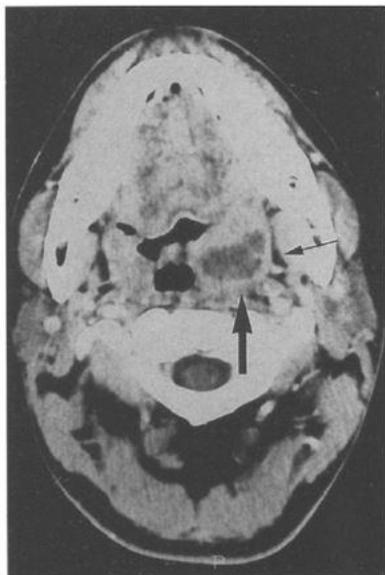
Postcontrast CT scan at level of oropharynx, showing left peritonsillar abscess (large arrow). Note that left parapharyngeal space is preserved (small arrow).
